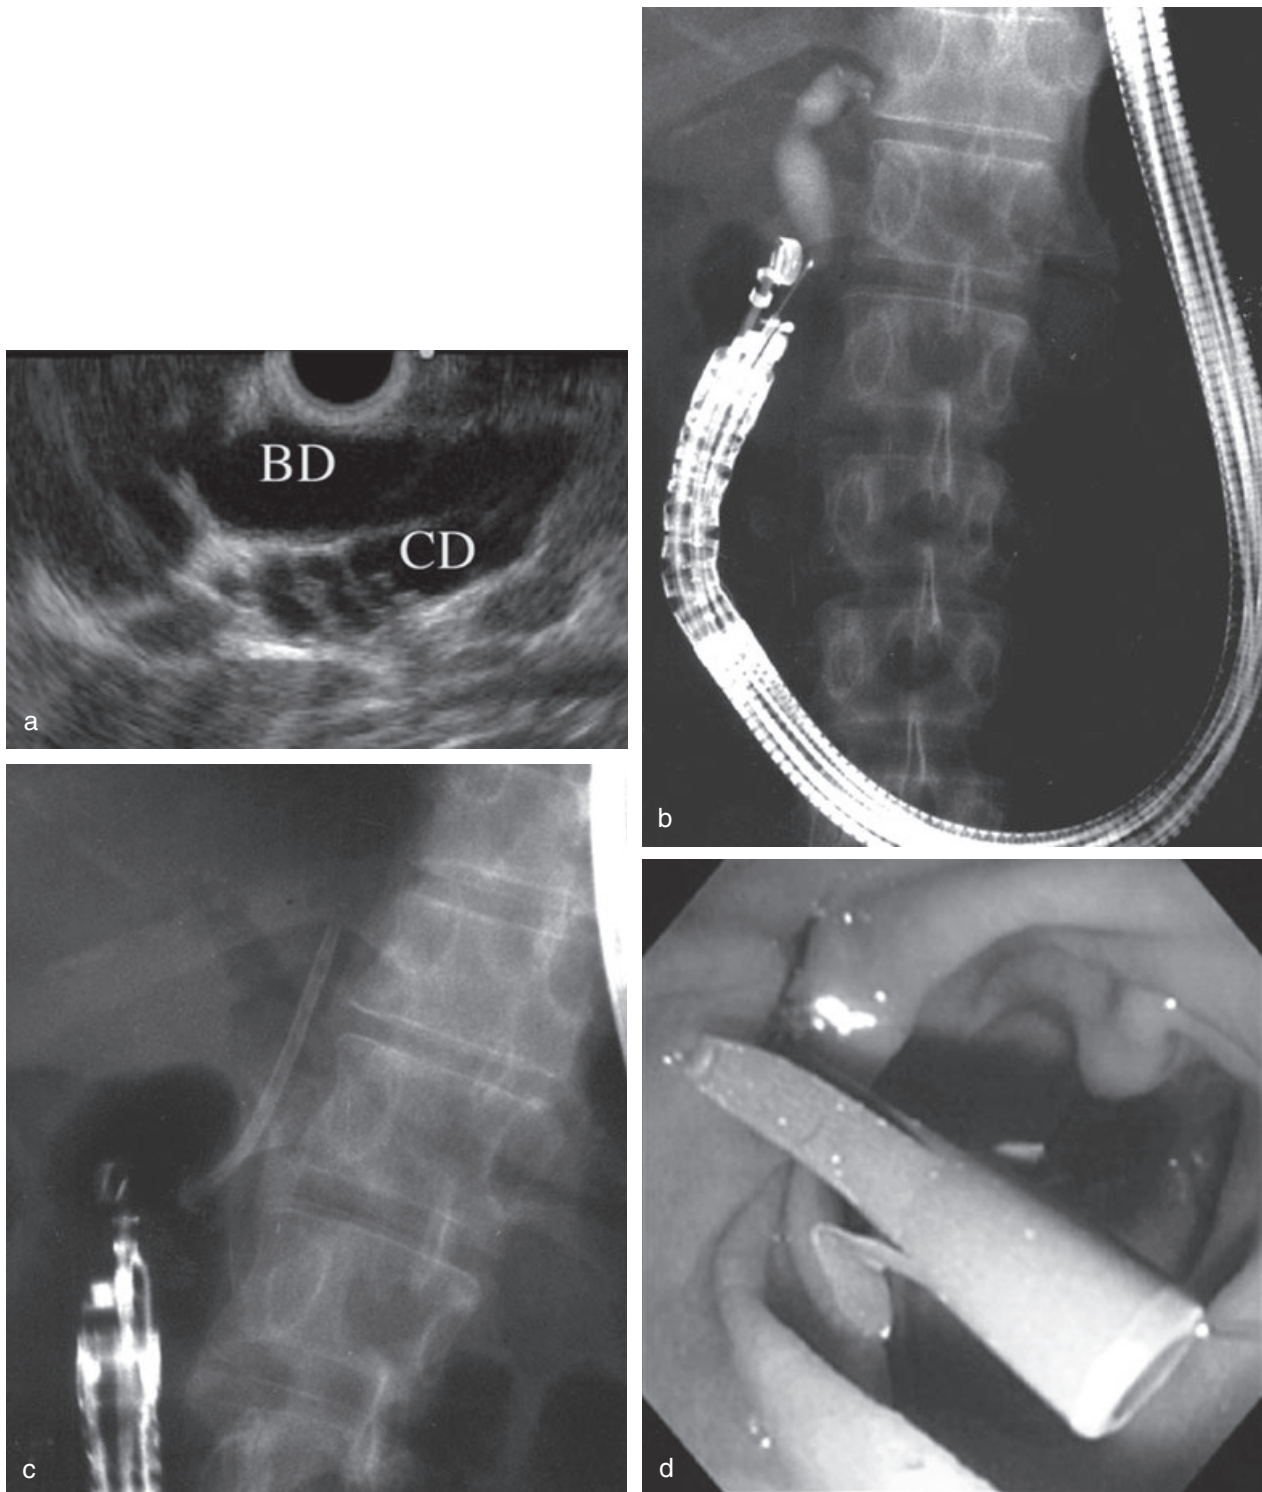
Endoscopic ultrasonography (EUS)-guided choledochoduodenostomy. (a) Convex echoendoscope, located in the apex of the duodenal bulb, clearly displayed the extrahepatic bile duct (CBD) and cystic duct (CD), (b) Cholangiogram obtained by EUS-guided puncture with the tip of the convex transducer directed to the hepatic hilum. The echoendoscope was observed in the long/pushing scope position, (c) Choledochoduodenostomy was accomplished using a tube stent in the apex of the duodenal bulb, (d) The stent was visible in the first portion of the duodenum.
